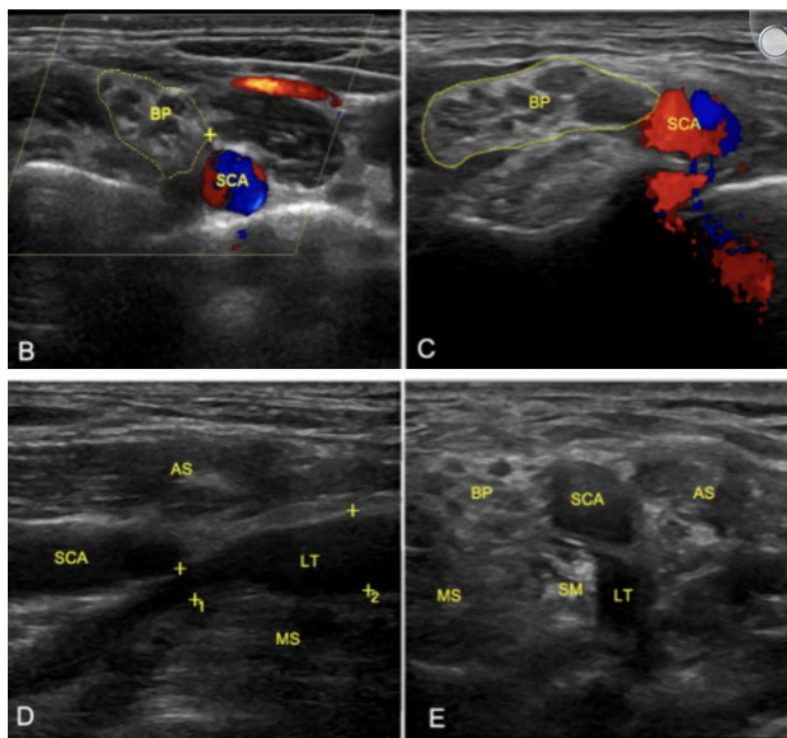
Ultrasound of the brachial plexus with and without Doppler: B) normal and C) injured side. Compare the cross-sectional view of the brachial plexus (BP) in these images. The BP is larger on the injured side. D) Longitudinal axis showing compression of the lateral trunk (LT) by the middle scalene (MS) muscle as is denoted by the measuring markers labeled 1; and E) short-axis view of the LT compression by the scalenus minimus (SM).
